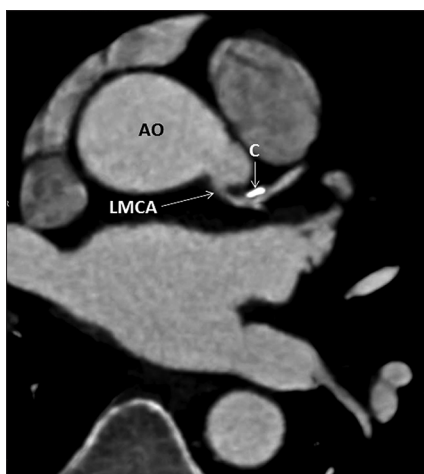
Preoperative computed tomographic coronary angiogram showing 90% localized stenosis in the left coronary ostium with an eccentric calcific plaque. The left anterior descending and left circumflex arteries were normal (AO: Aorta, LMCA: Left main coronary artery, C: Calcified atheroma)
